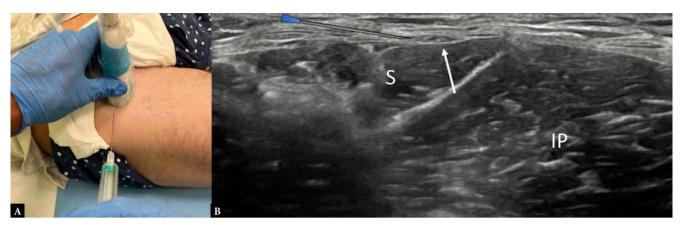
Ultrasound-guided injection of the lateral femoral cutaneous nerve. A. The patient is supine, and the linear probe is in transverse position at the level of the anterior superior iliac spine. B. The needle is advanced with in-plane lateral-to-medial approach to reach the lateral femoral cutaneous nerve (arrow) beneath the inguinal ligament and superficial to the sartorius muscle (S). IP – iliopsoas muscle
